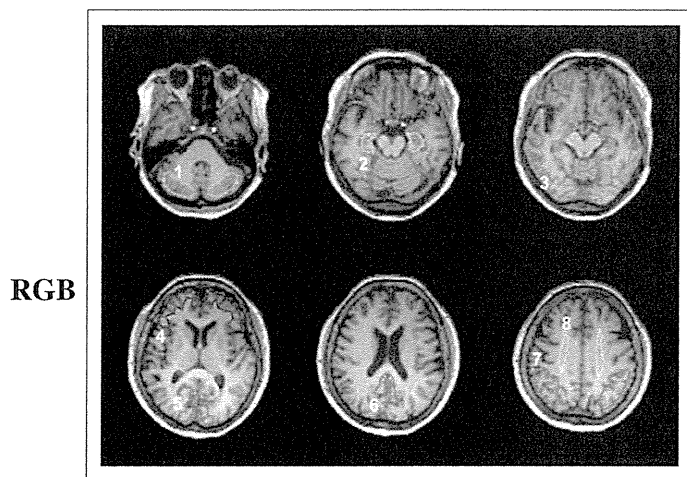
ROIs drawn on coregistered MR images. ROIs are defined for cerebellar cortex (1), parahippocampal gyrus including hippocampus (2), lateral side of temporal cortex (3), base side of frontal cortex (4), cuneus of occipital cortex (5), posterior region of cingulate gyrus (6), parietal cortex (7), and centrum semiovale (8).
